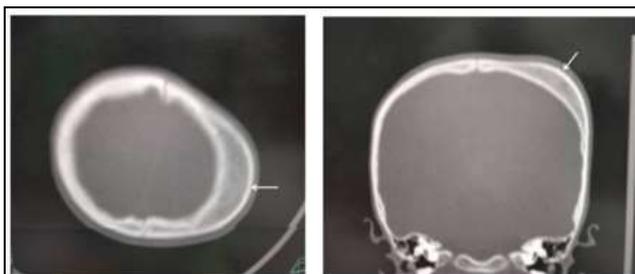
Plain CT Brain Axial and Coronal Sections in Bone Window Show Expansion of Left Parietal Bone with Ground Glass Matrix with Bulging of Outer Cortex (White Arrow)-Fibrous Dysplasia
